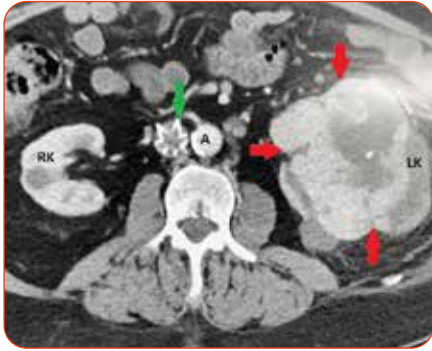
Axial enhanced CT scan showing a large lobulated mass in the left kidney (red arrows) in keeping with RCC. There is a 'star-shaped' metallic artefact (green arrow) in the IVC. It is an IVC umbrella that is used to prevent thrombi or spread of tumour emboli. RK = right kidney. A = aorta.
